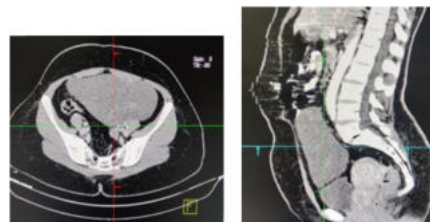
CT Scan images showing solid mass consistent with peritoneal leiomyoma
